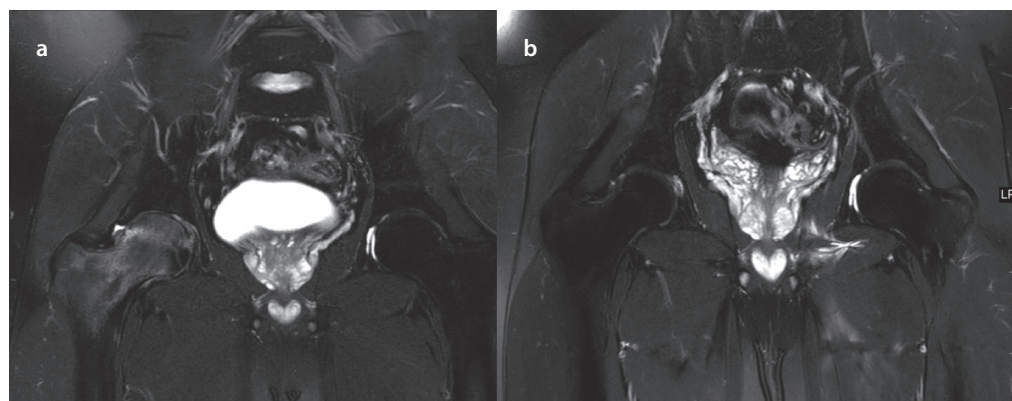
a, b. Magnetic resonance imaging (MRI) showing diffuse T2w hyperintense signal involving the head and neck of the right femur which is in keeping with marrow edema (a); complete resolution of the marrow edema in the right femoral head and no residual subarticular bone changes (b)
